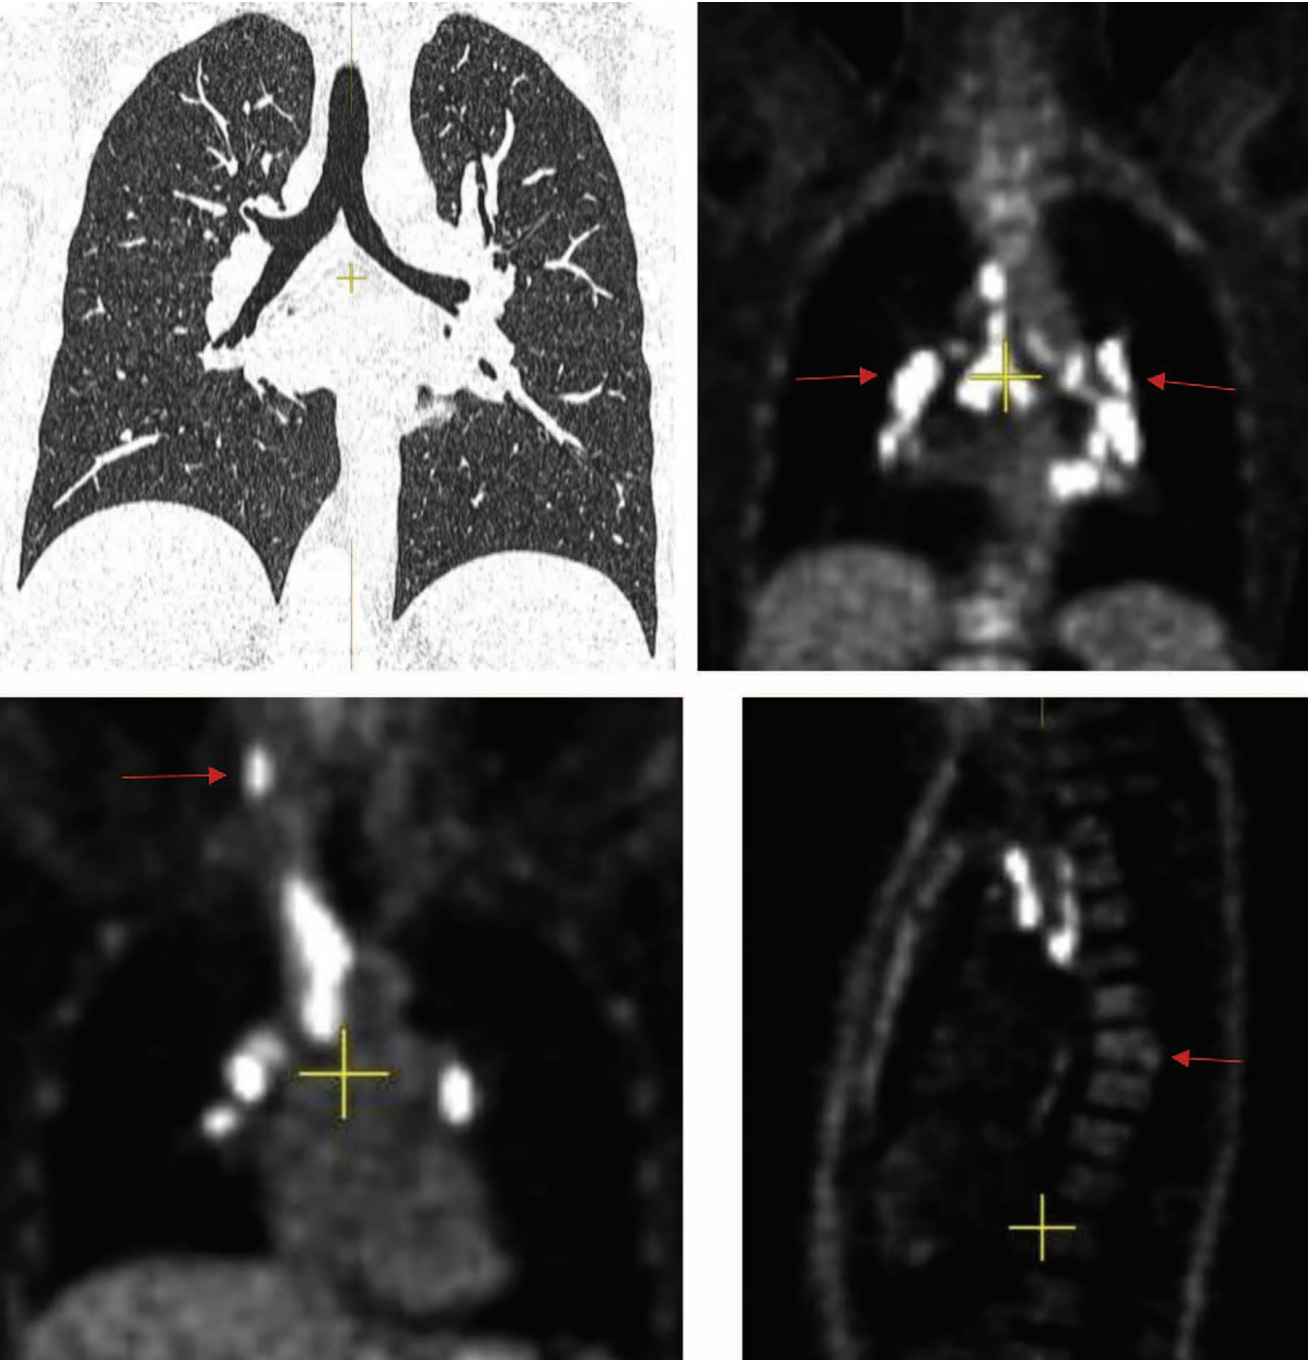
PET/CT scan with 18-FDG of the chest of patient C. Pathological metabolic activity of SUV in enlarged intra-thoracic lymph nodes, in enlarged right supraclavicular lymph node and in the spinal cord
